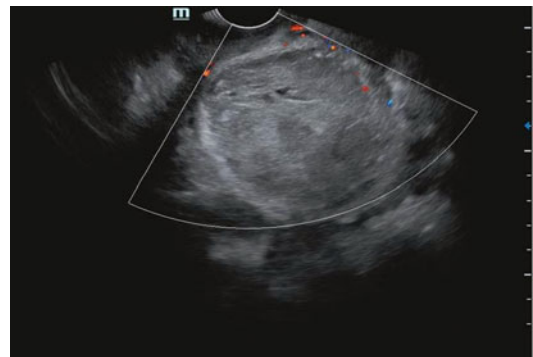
TVS with Doppler showing diffuse infiltrating endometrial cancer with uterine enlargement
